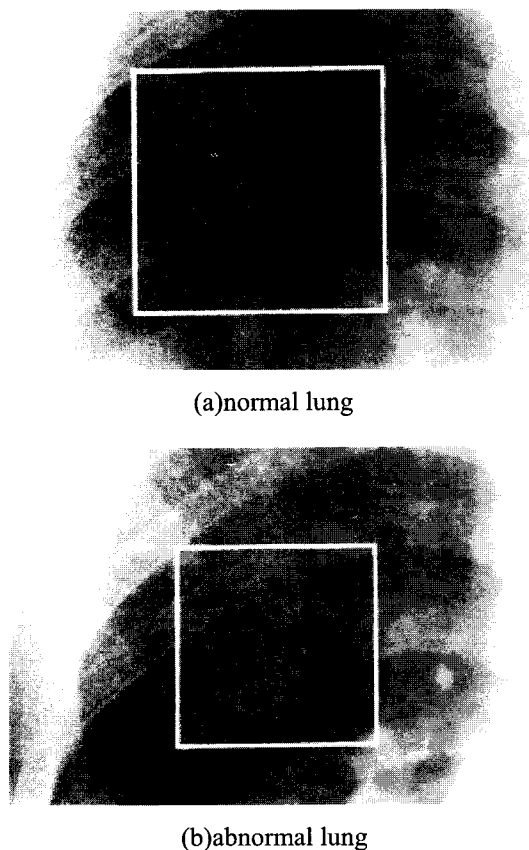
Chest radiographs of the right upper lung fields with ROIs.
